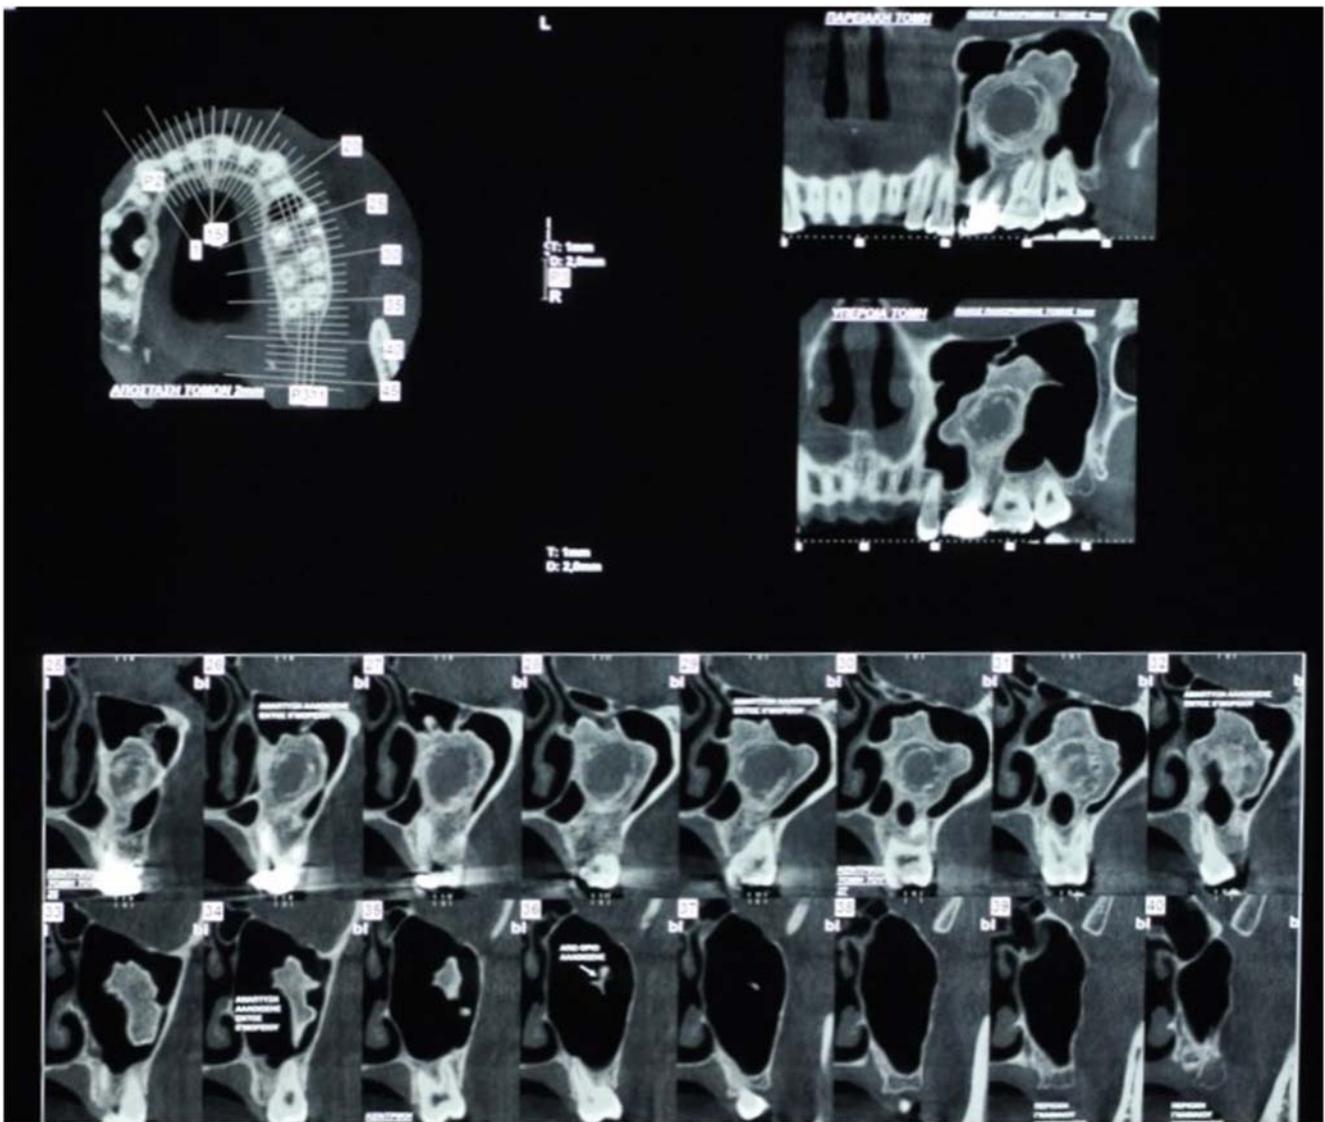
Preoperative CBCT in order to define dimensions and extension of the lesion. Frontal and vertical planes
